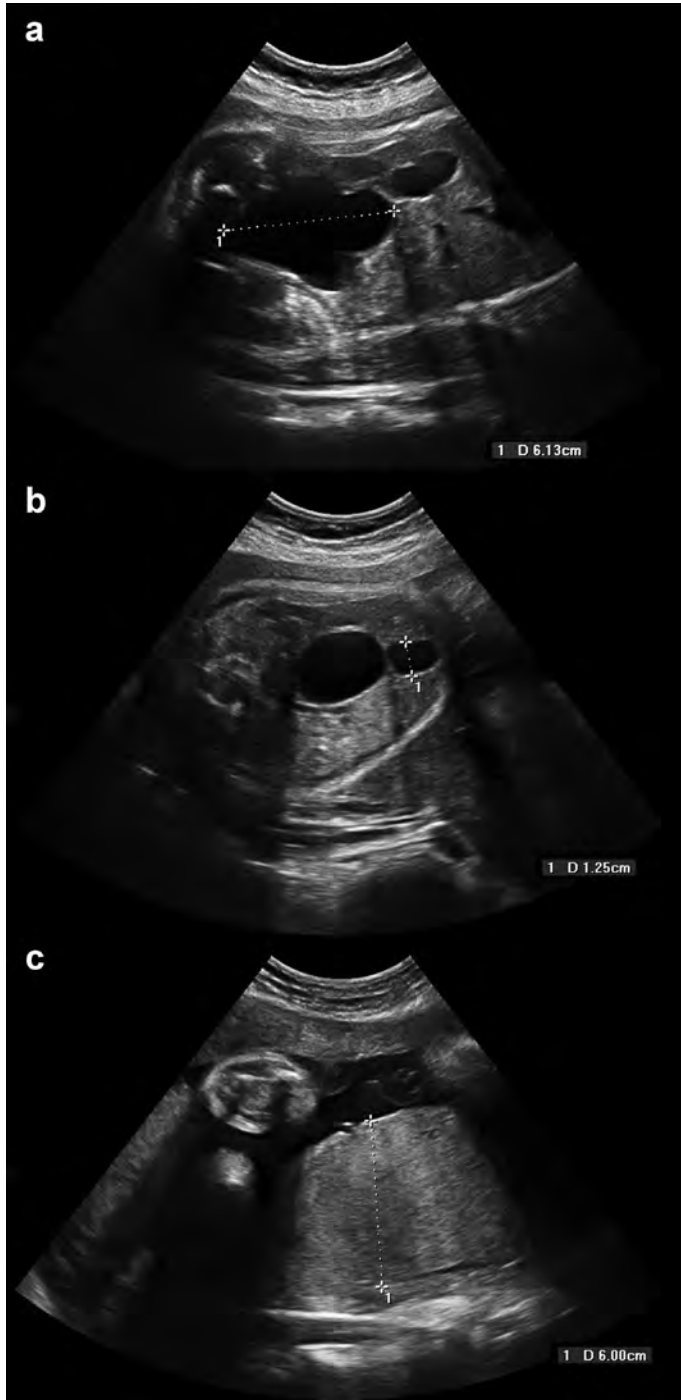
Prenatal ultrasound images (at 32 weeks gestation) showing an enlarged bladder, 6.13 cm in diameter (a), a umbilical vein varix, 1.25 cm in diameter (b) and a thickened placenta, 6.00 cm in diameter (c).
